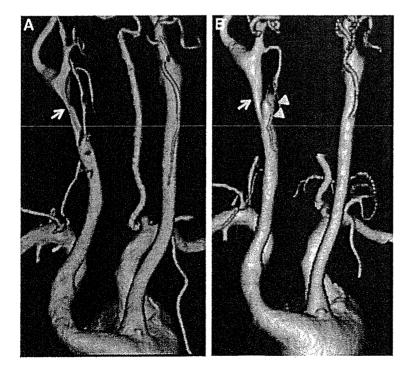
Cervical computed tomography angiography. A, On day 4, the right distal common carotid artery (CCA) is stenotic (arrow). B, On day 23, the stenotic CCA becomes wider (arrow), and aneurysmal formation is evident (arrowhead).
